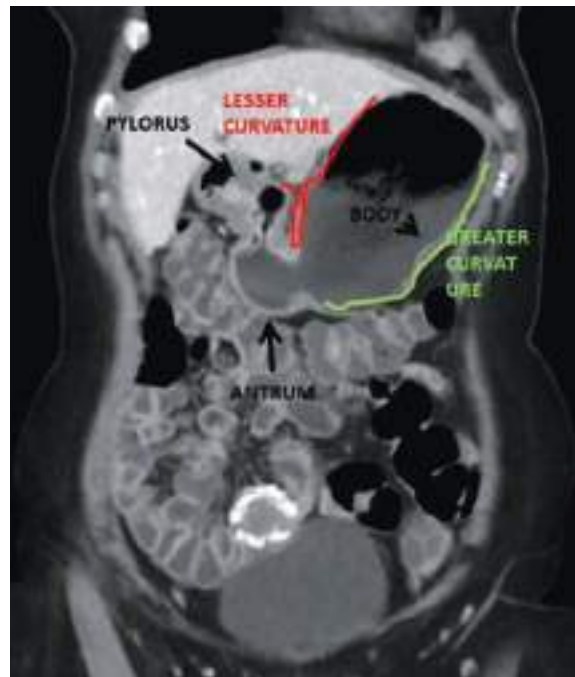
Stomach. (a, b) Coronal contrast-enhanced MPR CT image (portal venous phase). Note the presence of a subserosal uterine fibroid with coarse calcifications.
